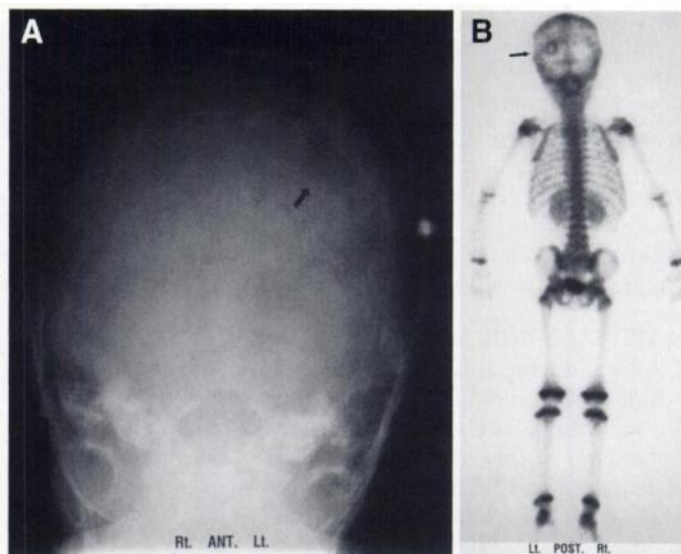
Four-year-old boy. (A) Townes radiograph projection of the skull showing a single lucent LCH lesion in the left occipital bone (arrow). (B) Bone scintigraphy (posterior view) shows avid increased radiotracer uptake surrounding a central photopenic area in the left occipital region (arrow). This corresponds to the lesion seen on the radiograph.
